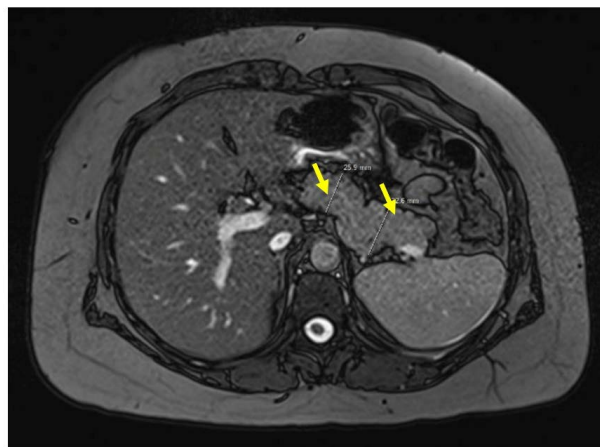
Axial computed tomography (CT) images showing edematous pancreatitis.
